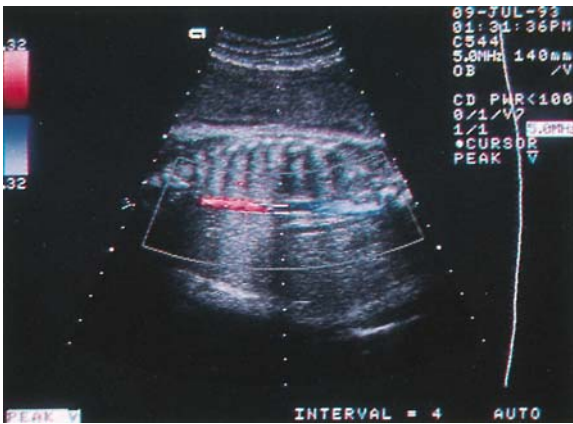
Doppler velocimetry of fetal descending aorta: original method combining a linear array real-time scanner and a 2-MHz pulsed Doppler instrument according to Eik-Nes et al. [4]. The Doppler transducer is firmly attached to the linear array transducer at an angle of  $45^\circ$  (*a*)
